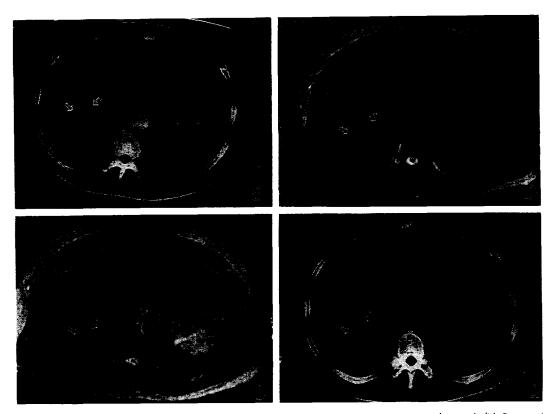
(a) Conventional CT revealed a small hyperdense area in the right lobe of the liver (arrows). (b) Conventional T2-weighted image showed a subtle mass lesion in the right lobe of liver (arrows). (c) CSIC-enhanced T2-weighted image revealed a hyperintense mass lesion (arrows) with markedly decreased signal intensity of surrounding non-tumorous liver parenchyma. (d) CTAP revealed a small hypoattenuated portal perfusion defect in the right lobe of liver (arrows).
